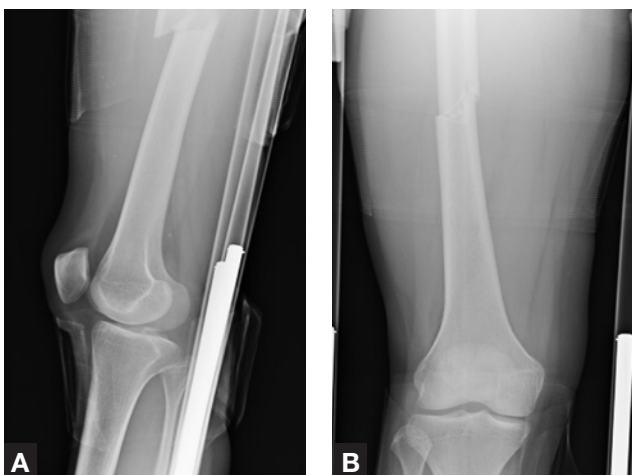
Lateral (A) and anteroposterior (B) x-rays of injury.
